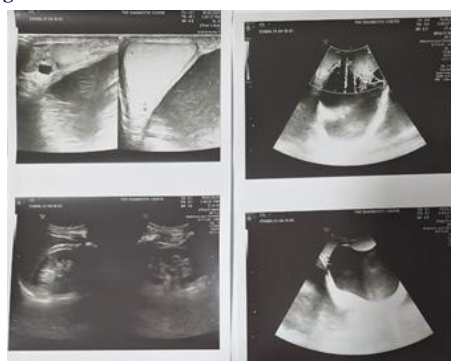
Scrotal ultrasonography images showing a large cystic swelling arising from left epididymal head of size measuring 14.3 X 6.5 cms with both testes normal in size, shape, and location.
